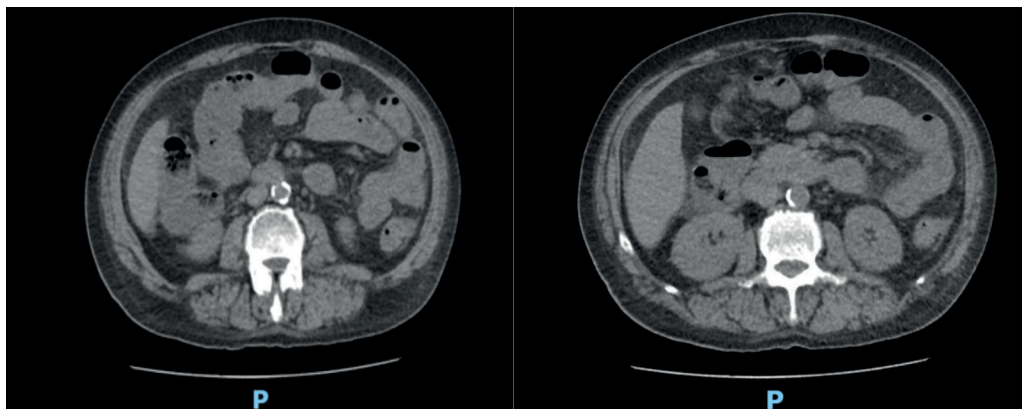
Abdomen CT Scan images showing gas bubbles indicating bowel perforation.
